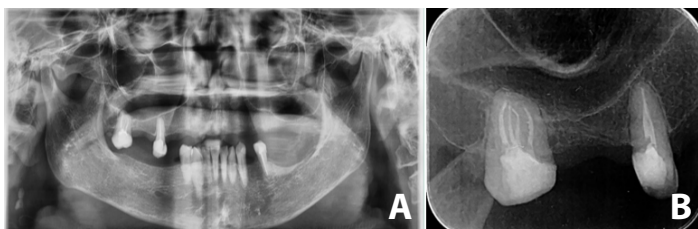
A. Panoramic radiograph, B. Periapical radiograph
